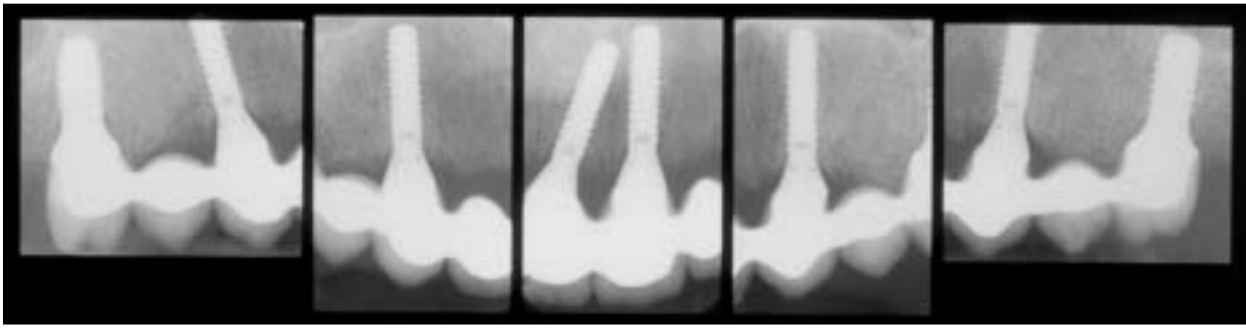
The osseous contour and its relationship to the contact point of each connector of the final fixed prosthesis are shown in the radiographs. The location of the junction of the crown margin/implant microgap was at least 2 mm coronal to the crestal bone. Therefore, no resorption should occur secondary to an anticipated biologic width response. Without osseous resorption, the overlying soft tissue would be expected to remain stable.
